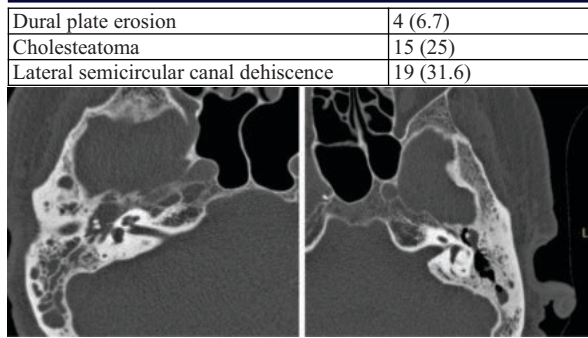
HRCT Temporal Bones Showing soft tissue density in the middle ear and ossicular erosion
